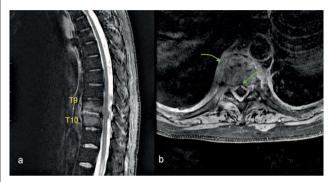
a) Sagittal short-tau inversion recovery (STIR) MR image: High signal involving both T9 and T10 vertebral bodies and the intervertebral disc consistent with spondylodiscitis, is observed. b) Axial T1-weighted image with fat saturation post gadolinium: Diffuse strong enhancement is shown in the vertebral body, the paraspinal soft tissue mass (curved green arrow) and the adjacent right rib with infiltration of the epidural space (straight green arrow).
